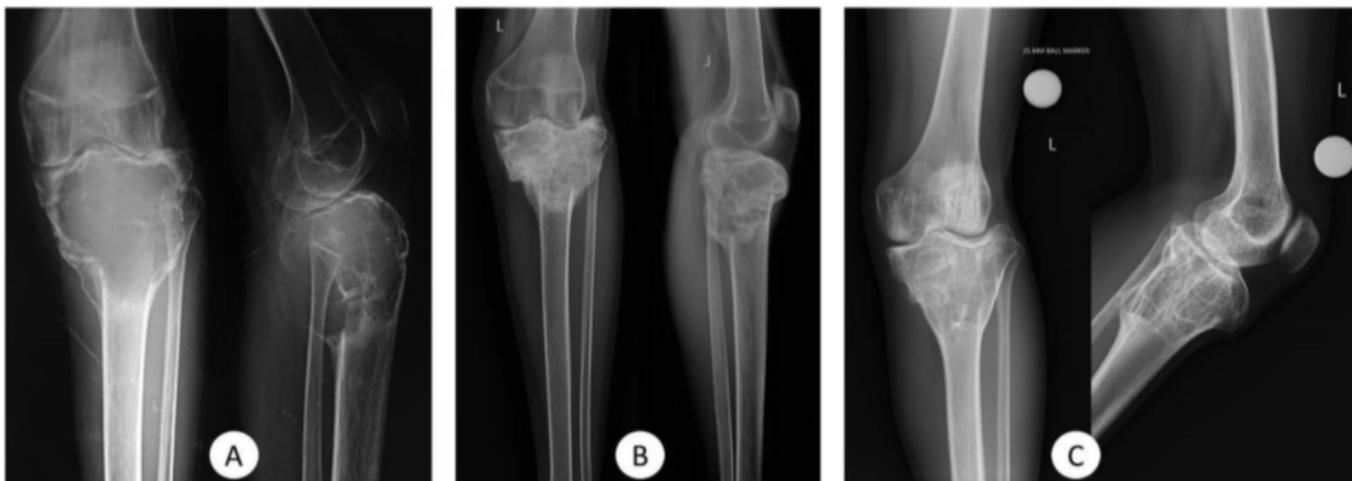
A-C This is a patient with a proximal tibia GCT with (A) a radiograph at presentation who was treated with denosumab only. (B) This is a radiograph after eight injections and 6 months of therapy with denosumab showing sclerosis around and ossification within the tumor. He discontinued denosumab after a total of eight doses and continues to remain disease-free as seen on (C) a radiograph at latest 2-year followup.
